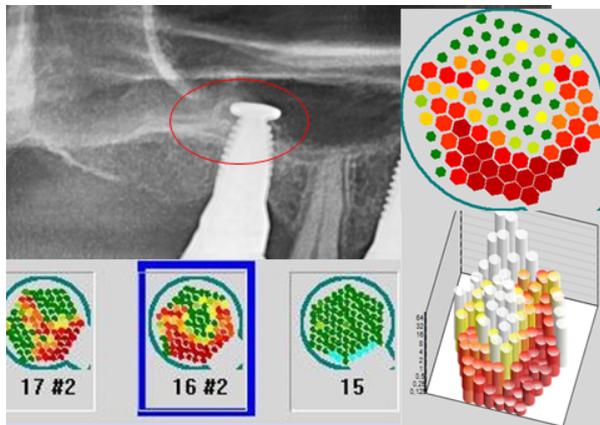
2D-OPG shows ceramic implant, placed about 9 months ago. The X-ray does not give any indication of a possible cause for atypical facial pain since insertion. Bottom left image shows the overview measurement with CaviTAU®: According to the CaviTAU® measurement, the conspicuous areas with possible osteolysis indicated by red colouration are towards to the apical area of implant 16, with clear osteolysis. Right image: Relatively high degree of bone loss around the implant indicated by red color codes. The 3D-CaviTAU® image shows the implant in white and the surrounding diminished bone density in red.
